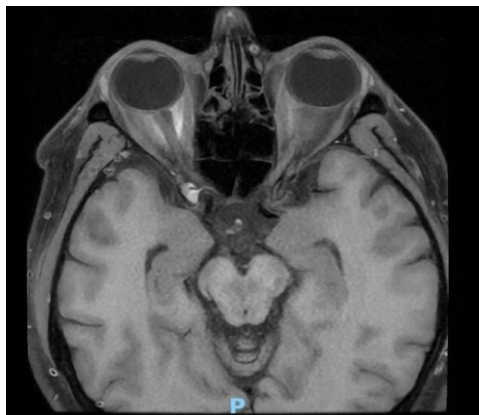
MRI showed a soft tissue lesion in the right orbital apex extending into the right cavernous sinus
